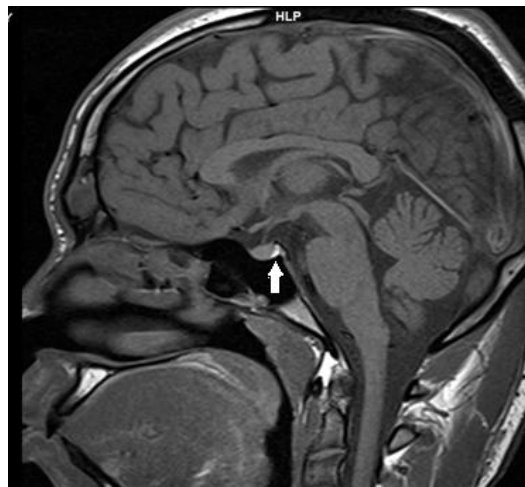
The Brain MRI of the patient, with an arrow pointing at the preserved bright spot of the posterior pituitary gland on a T₁ weighted image
